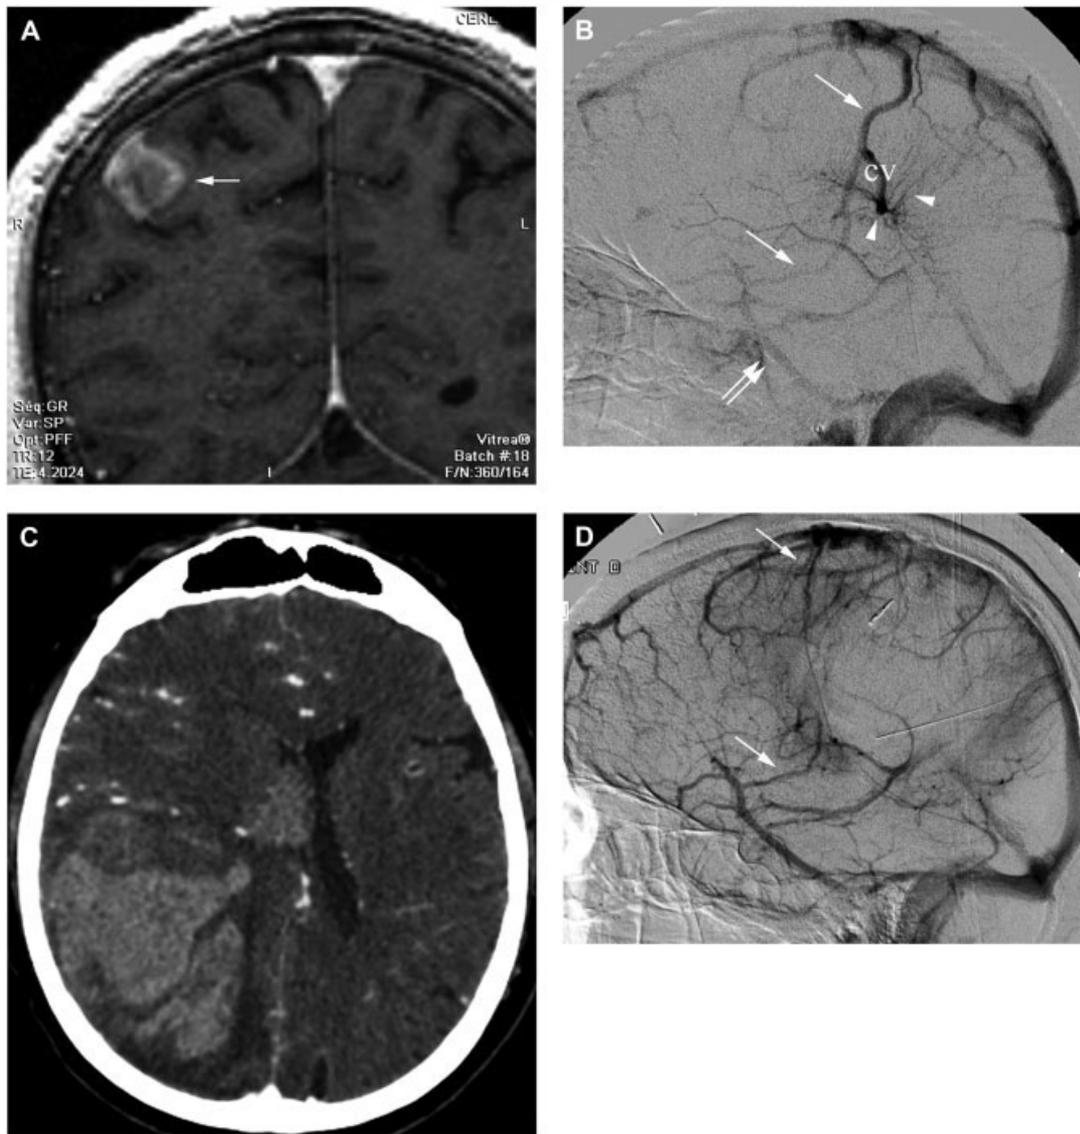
A 50-year-old man who presented with a small post-Rolandic hemorrhage. (A) Coronal, Gd-3D T1-weighted image showing the hemorrhagic lesion (arrow). (B) Right carotid artery injection, lateral view of the venous phase showing the typical caput medusae of the DVA (arrowheads) and the collecting vein (cv) draining into the greater anastomotic vein of Trolard (arrows). The latter was connected to a lesser anastomotic vein of Labbé (double arrow). No thrombosis of the DVA was discernible at that time. (C) Four years later, the patient presented with a lobar fronto-parieto-temporal and intraventricular hemorrhage, seen here on this axial CT angiography (CTA) source image. (D) Right carotid artery injection, lateral view of the venous phase; the DVA and the middle segment of the greater anastomotic vein of Trolard are no longer visible due to acute thrombosis. The proximal and distal portions of the greater anastomotic vein of Trolard are still patent (arrow).
